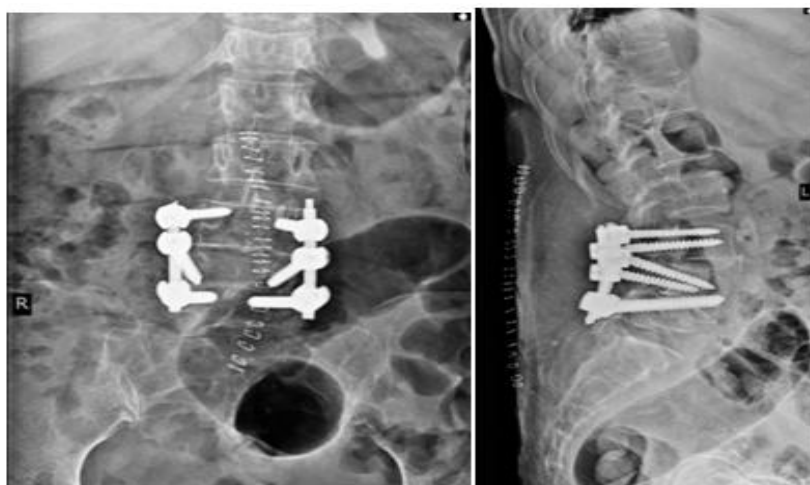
Postoperative X-ray of lumbosacral spine showing implant in-situ
